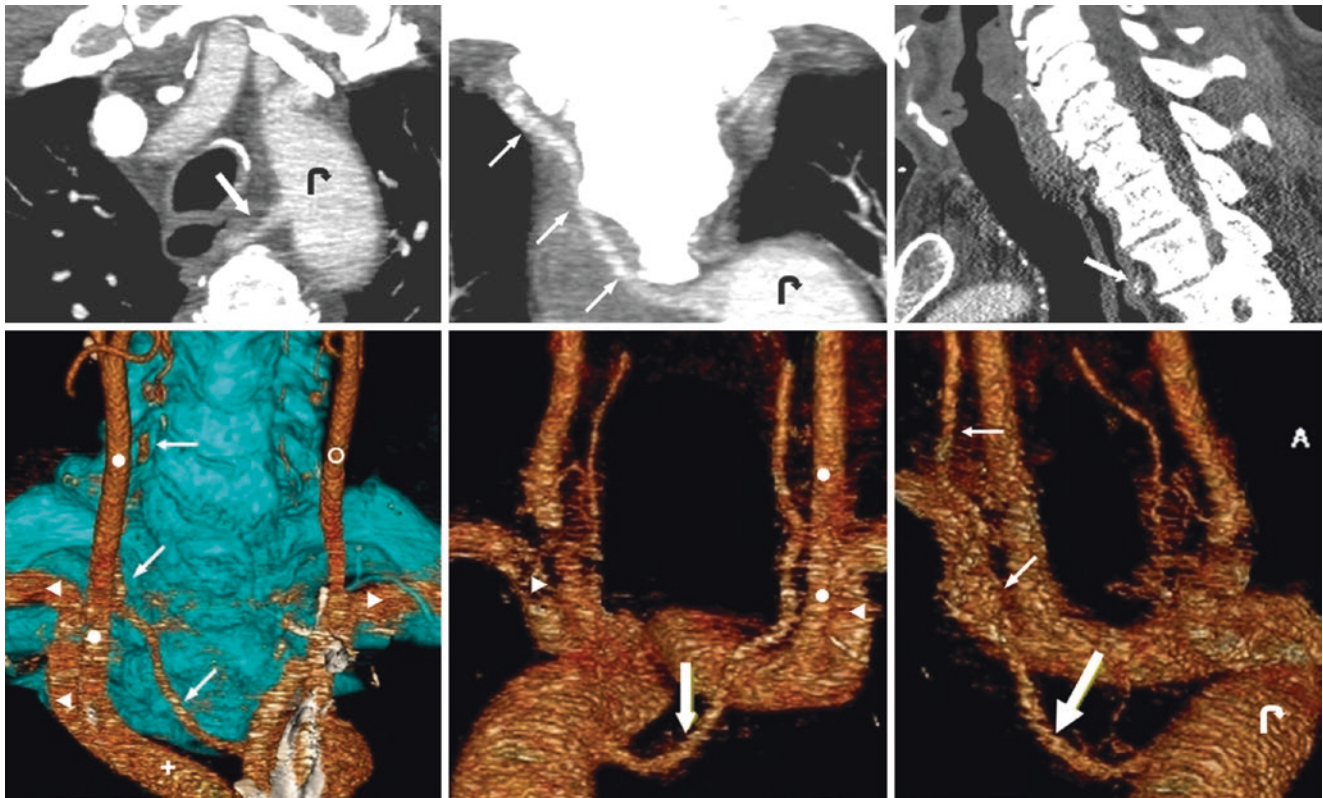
A 78-year-old with a left-sided arch had an aberrant, retroesophageal RVA (arrows) arising off of the aorta, on various CTA MPRs, including axial (top left), coronal (top middle), and sagittal (top right) views. On 3D VR AP (bottom left), posterior (bottom middle), and right lateral (bottom right) views, the RVA's course is delineated. *Aortic Arch* (curved arrows); *IA* Innominate Artery (+); *LCCA* Left Common Carotid Artery (○); *LSCLA* Left Subclavian Artery (▶); *RCCA* Right Common Carotid Artery (●); *RSCLA* Right Subclavian Artery (◄)
